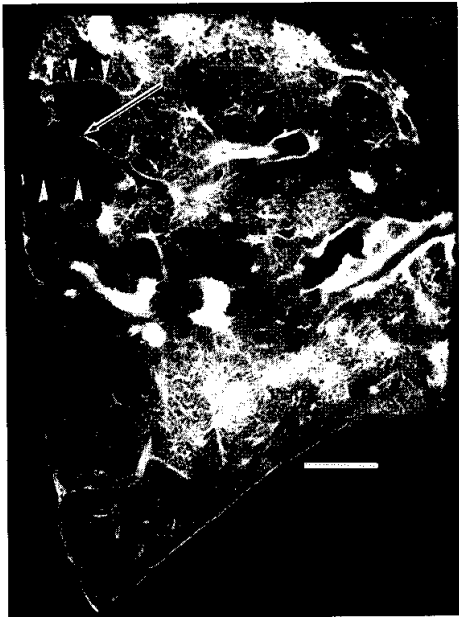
Contact radiograph of a lung slice isolated from a 85-year-old woman with bronchogenic spread of tuberculosis who had a history of antituberculous chemotherapy showing lobular emphysema due to bronchiolar stenosis. Bar indicates 10 mm. Note fibrous stenosis of the bronchiole (arrow) resulting in lobular emphysema (arrowheads).
